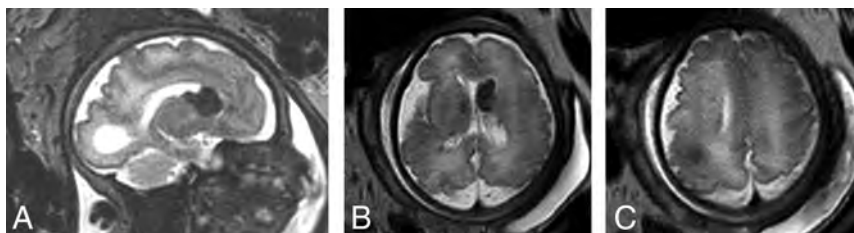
Thirty-two to 40 weeks' gestation. 3T, single-shot T2-weighted EPI shows the foramen of Monroe dominant nodule/enlarged GE (A and B) and cortical tuber (C).
